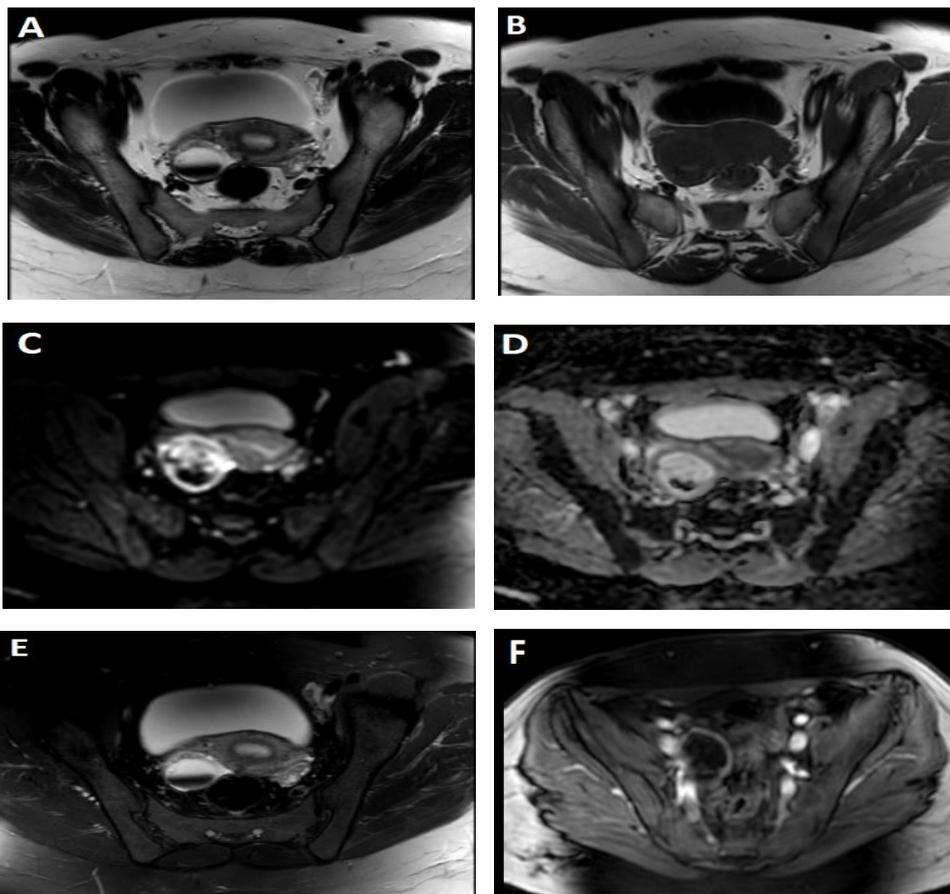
(A) Axial T2-weighted sequence showed right ovarian unilocular cystic lesion with fluid-fluid level. (B) Axial T1-weighted sequence showed a hypointense ovarian cyst. Both (C) DWI & (D) ADC maps showed internal foci of restricted diffusion. (E) Axial fat suppression T2WI revealed no fat suppression. (F) Contrast-enhanced axial T1WI showed thin wall enhancement of the cyst. O-RADS MRI score was 2, Non-Contrast MRI score was 2.
